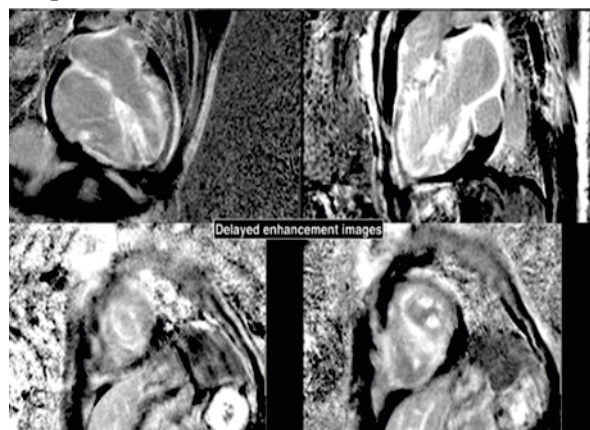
Cardiac MRI Showing Diffuse Delayed Enhancement, Thickened Myocardium Suggesting Cardiac Amyloidosis.
